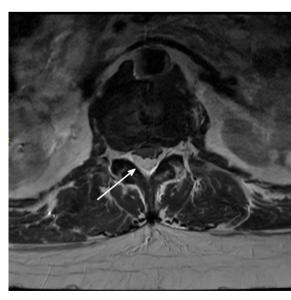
MRI Lumbar: Thoracolumbar epidural abscess primarily present dorsally also extends ventrally. Results in multilevel cauda equina compression with compression of the thecal sac to 3-5 mm. Compression present at L1-L2, L2-L3, L3-L4, and the L4 vertebral body level. Medial left posts muscle abscess at the lumbosacral junction with greatest cross-sectional dimensions of only 1.7 x 1.2 x 3.3 cm (not imaged).
